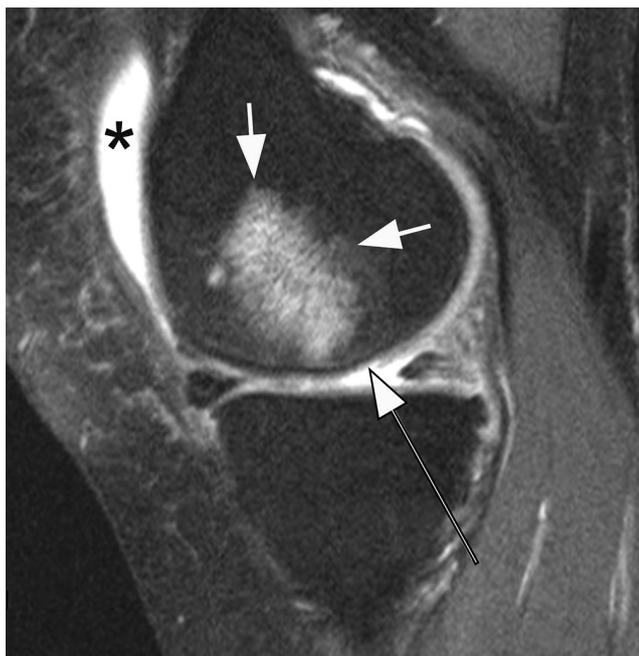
Subchondral bone marrow lesions. Sagittal intermediate-weighted fat-suppressed MRI shows a large bone marrow lesion in the central subregion of the medial femur (short arrows), representing an OA feature that is associated with pain and structural progression. Additional concomitant MRI features of OA, including effusion-synovitis (asterisk) and superficial focal cartilage damage in the central part of the medial femur (long arrow), are also visible on MRI. Size of the BML characterises this knee as exhibiting a “subchondral bone” phenotype.
